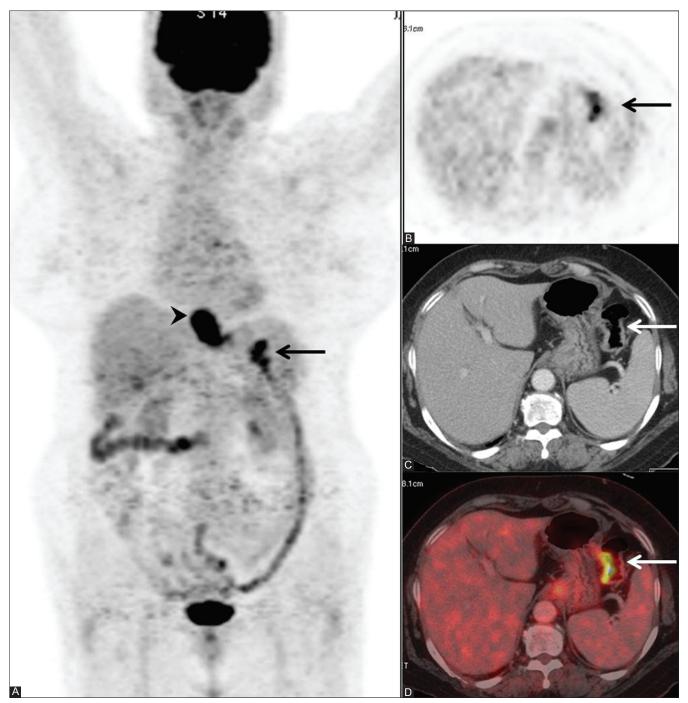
(A-D): A 74-year-old man treated for NHL referred for a restaging FDG PET/CT (pt # 17). Focus of intense FDG uptake (SUV<sub>max</sub> 34.5) is seen in the abdomen on the whole body maximum intensity projection (MIP) and axial PET images (arrows in A and B). The focus of uptake seen on the MIP and the axial PET correlates with a small soft tissue density in the hepatic flexure seen on the CT image (arrow in C) and is confirmed on fusion image (arrow in D). Colonoscopy revealed a pedunculated polyp and pathology confirmed the diagnosis of an adenomatous polyp with moderate-grade dysplasia
